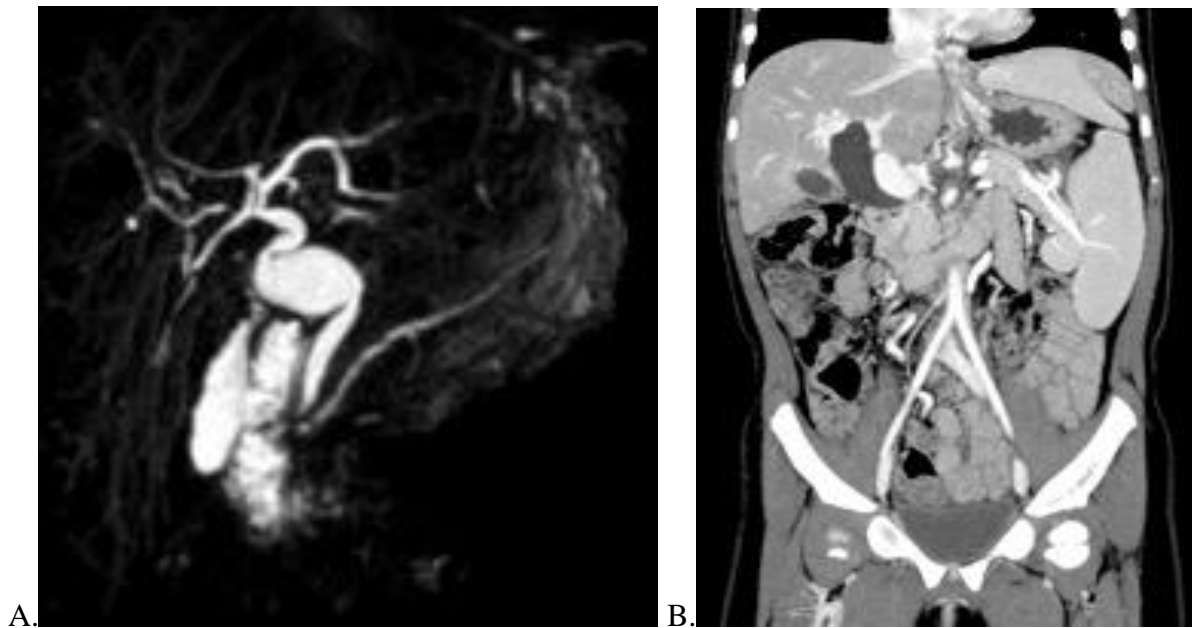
Image of CC magnetic resonance cholangiopancreatography (A) and CT scan (B)
